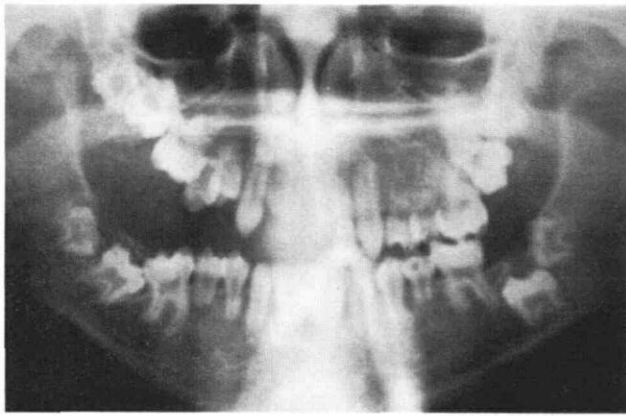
(above) Panoramic radiograph reveals delayed eruption of maxillary and mandibular permanent right first molar and premolars, short roots with open apices, and impaction of the mandibular second molars.
